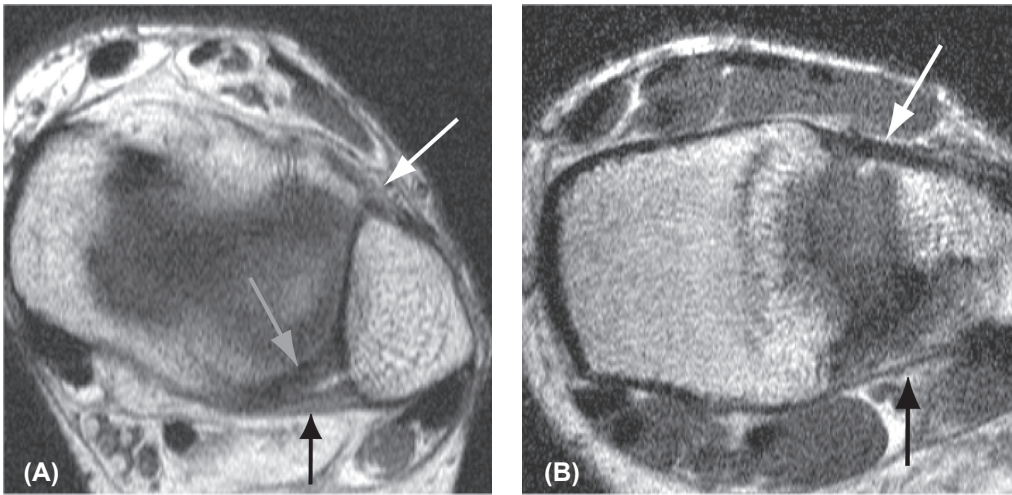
Axial (A) and oblique (B) T1-weighted TSE image of the anterior distal tibiofibular ligament in a healthy volunteer. The axial image (A) shows a discontinuous aspect of the inferior fascicle of the ATIFL, also called Bassett's ligament (white arrow). In the oblique image (B) a thick continuous Bassett's ligament is visible. Posteriorly the transverse ligament (gray arrow) and posterior tibiofibular ligament (PTIFL; black arrow) are depicted; in the oblique plane (B) only the lowermost fascicle of the PTIFL is depicted at this level.
